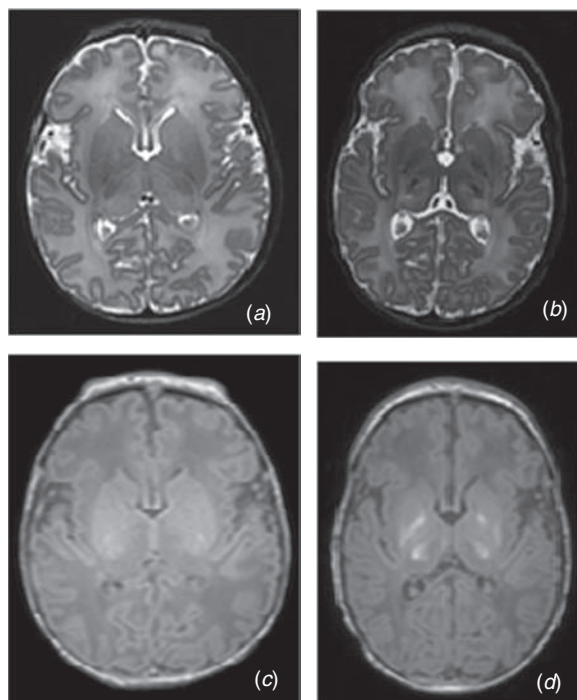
Evolution of basal ganglia and thalami (BGT) lesions in a term-born infant with hypoxic-ischemic encephalopathy (HIE). Images at (a, c) four and (b, d) 18 days: (a, b) T2- and (c, d) T1-weighted sequences. Appearances of the BGT at four days are not normal. There is a reduced signal intensity from myelin in the posterior limb of the internal capsule (PLIC) in (c) whereas in (a) the low signal intensity from myelin is excessive. The abnormal signal intensities have evolved so that at 18 days of age the changes are very obvious. In addition, on the later scans (b, d) in both sequences the signal intensity within the PLIC is absent.
